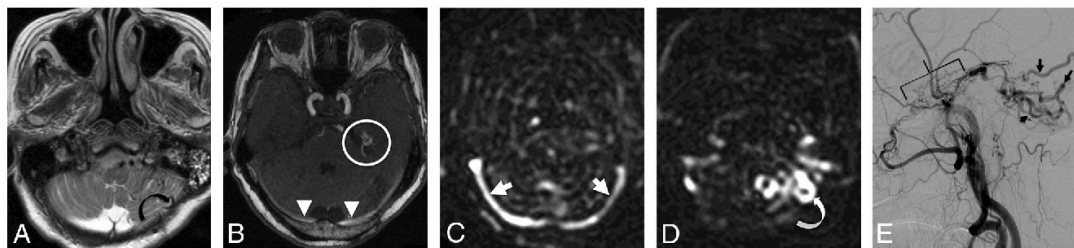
A 79-year-old woman presenting with ataxia. *A*, T2-weighted imaging demonstrates tortuous and ectatic pial veins (*curved black arrow*) along the inferior surface of the left cerebellar hemisphere. *B*, MIP TOF-MRA image demonstrates nodular and curvilinear hyperintensities immediately superior to the left petrous apex, representing a left tentorial fistula (*white circle*) and high signal in the transverse sinuses (*white arrowheads*). *C*, pCASL image shows venous ASL signal in the transverse sinuses (*white arrows*) due to shunting. *D*, More inferiorly, venous ASL signal is seen in draining pial veins (*white curved arrow*). *E*, DSA image following left external carotid artery injection confirms a Cognard type IV left tentorial DAVF (*bracket*) with a middle meningeal artery supply and drainage directly into ectatic cerebellar cortical veins (*black arrows*).
